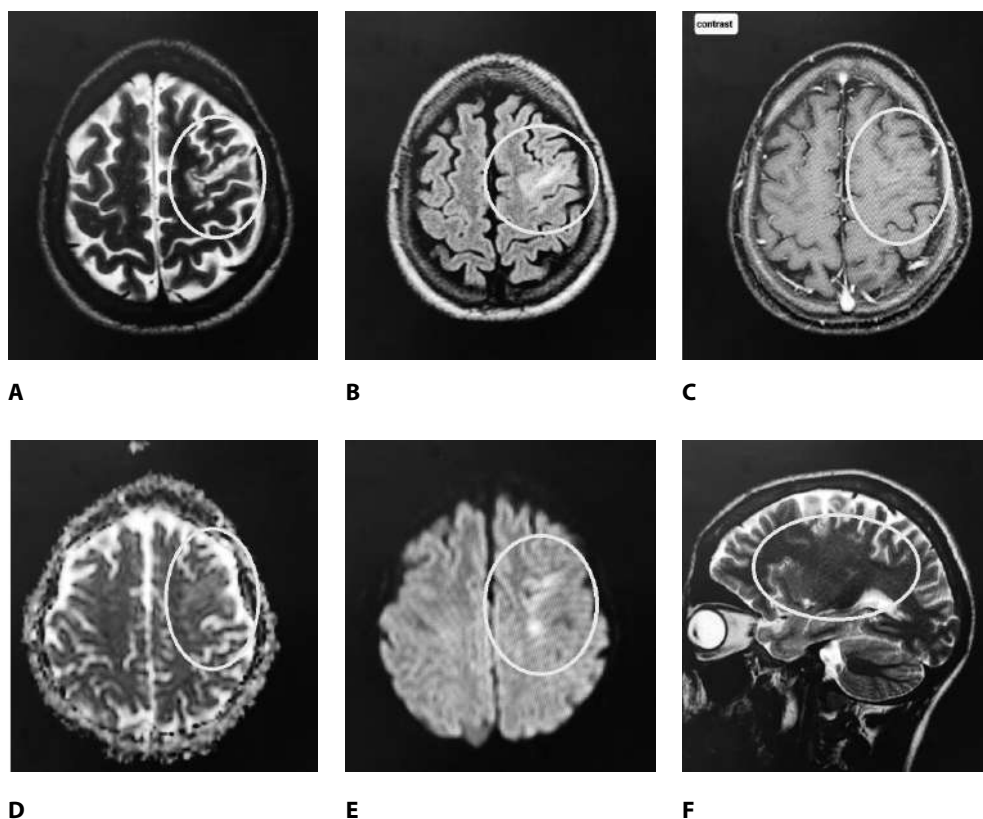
15-years-old young boy: Dysembryoplastic neuroepithelial tumor (DNET): is a low-grade, slow-growing brain tumor: A. T2WI axial: Left posterior frontal cortical and subcortical high signal lesion with bubbly appearance. B. FLAIR axial: Left posterior frontal cortical and subcortical partially suppressed high signal lesion with bubbly appearance. C. T1 axial + GD contrast: mild heterogenous enhancement. D. ADC: Non significant. E. DWI: Non significant. F. T2WI sagittal: Cortical / subcortical bubbly high SI lesion
